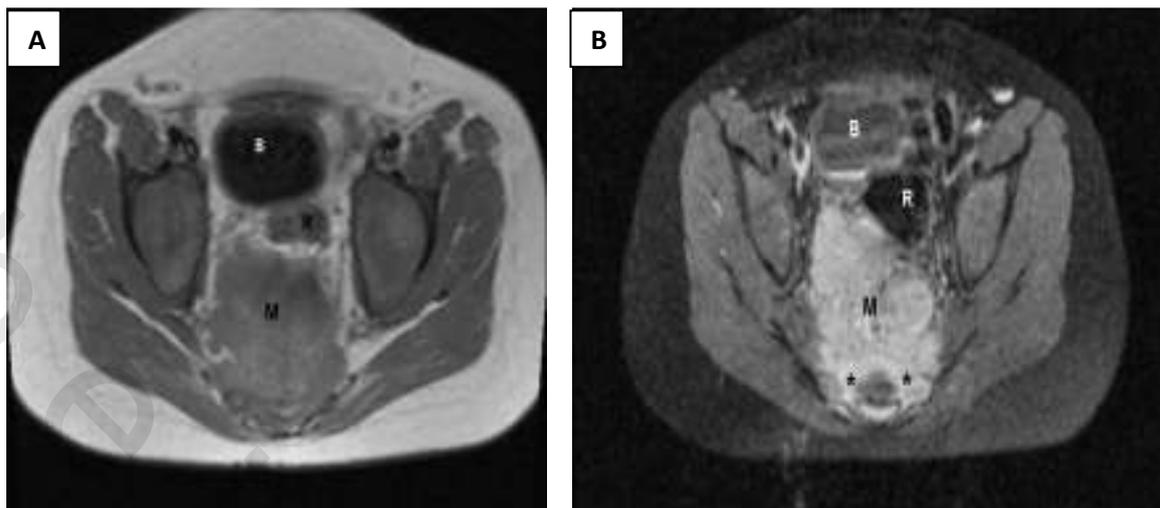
Case 8: (A) axial T1 (B) axial T1 Fat-Sat after GAD injection. MRI shows a sizable presacral soft tissue mass (M) with intra thecal and intra osseous components. The lesion showed isointense signal on T1, hyper intense signal on T2, moderate inhomogeneous contrast enhancement and restricted diffusion. Infiltration of the mass posteriorly into the sacral vertebrae and neural foramina (*) is evident. The rectum (R) is pushed anterolaterally with no signs of infiltration. B: urinary bladder. Imaging features suggested an aggressive mesenchymal lesion with chordoma on top of differential diagnosis because of the anatomical site, the age and the infiltrative nature. Chordoma was found on pathology.
